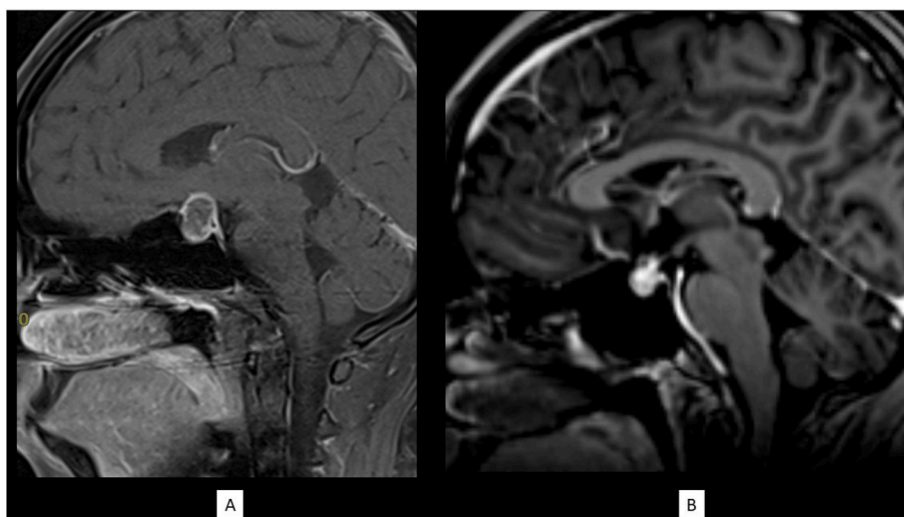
Sagittal T1 post-contrast at presentation (a) in comparison with the reassessment MRI performed one month later (b). There is approximately 50% reduction in the pituitary mass lesion size.
